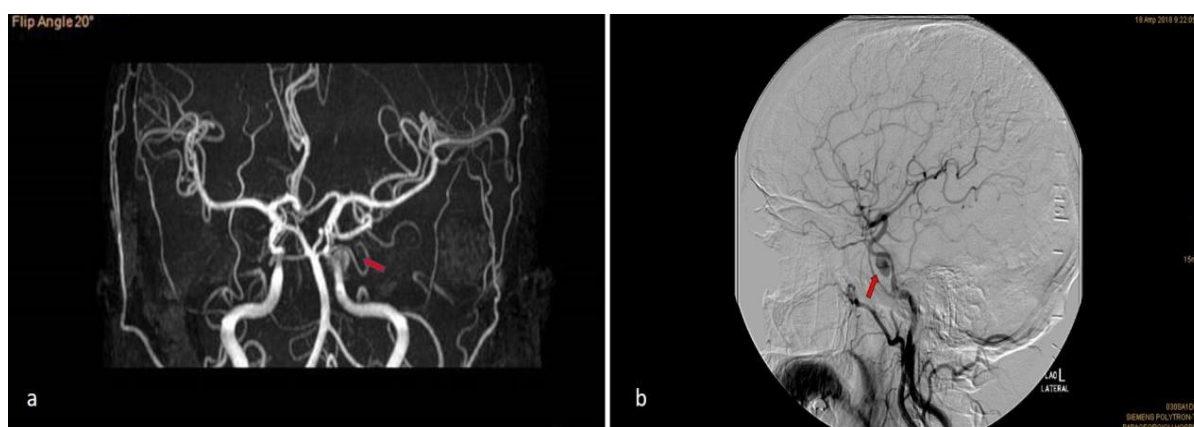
MRI angiography (a) demonstrating an intracavernous aneurysm of the left internal carotid artery (red arrow). Cerebral angiogram (b) lateral projection after contrast injection into the left internal carotid artery demonstrating a large (~1 cm) aneurysm of the left cavernous internal carotid artery (CICA) with anterior bend and pre-aneurysm stenosis of the left ICA (Red arrow)
